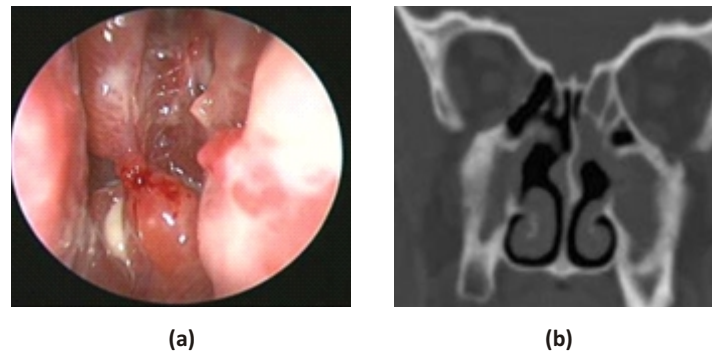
(a) Endoscopic view of acute exacerbation of chronic rhinosinusitis in osteitis. (b) Coronal sinus CT scan shows hyperostotic ethmoid thickening with concomitant mucosal thickening.
